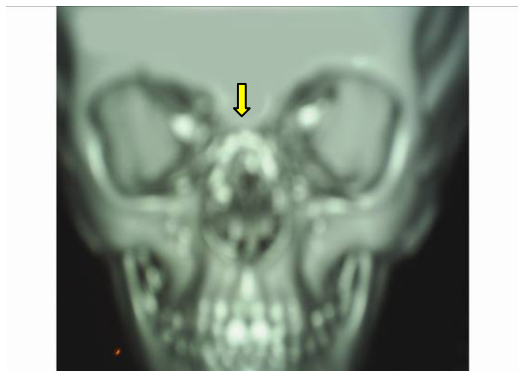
Postoperative picture reconstructed 3D CT of case no. 1 showing miniplates fixed on the nasal bone &bridge
